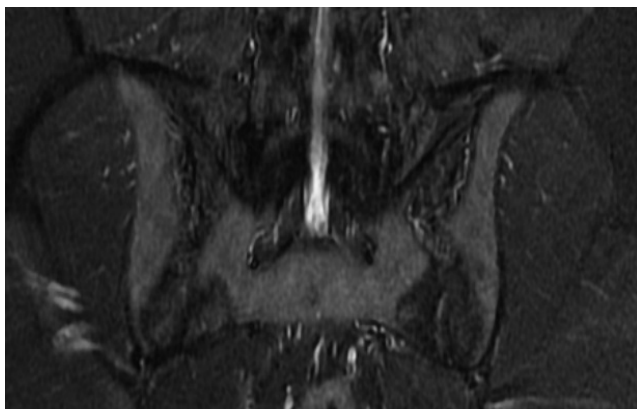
T2-weighted magnetic resonance imaging of sacroiliac joints supported bilateral chronic sacroiliitis
